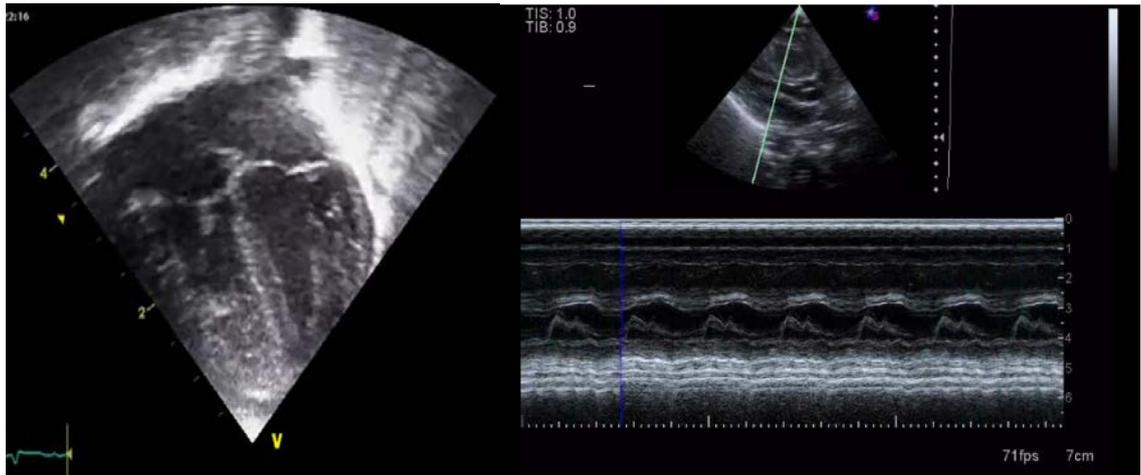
B-Mode (left) and M-Mode ultrasound imaging of the neonatal heart (right)
